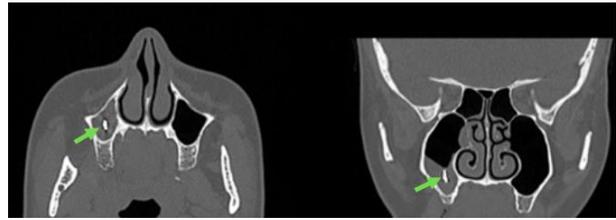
Axial and coronal CBCT images shows iron-like opacity.
